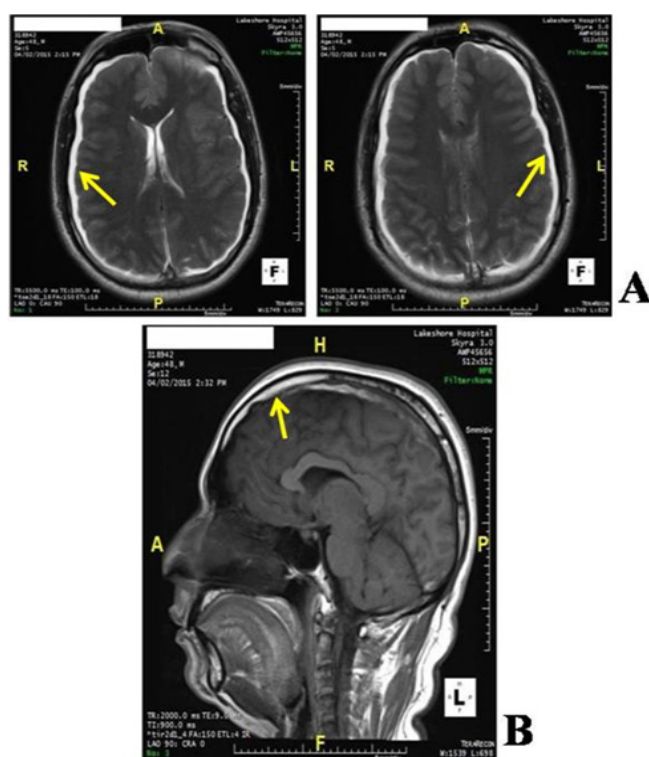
MRI brain. (A) T2 weighted sequences showing bilateral symmetrical fronto-parietal and occipital subdural effusions (as marked by the arrow); (B) T1 weighted sequences showing sagittal sinus thrombosis (as marked by the arrow)
